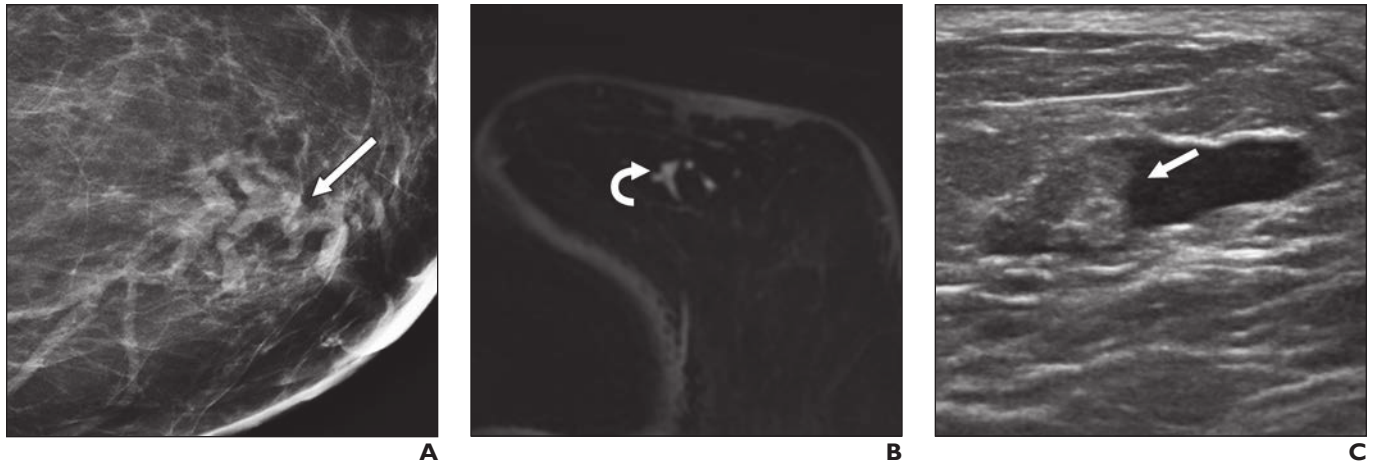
41-year-old woman with atypical lobular hyperplasia (ALH) found at MRI-guided biopsy (targeted lesion was missed at MRI-guided biopsy) that was upgraded to ductal carcinoma in situ (DCIS) at follow-up excision. Asymmetry was noted on craniocaudal mammogram (not shown).
